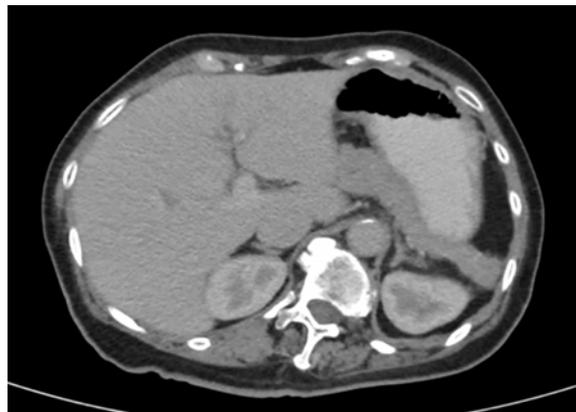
Horizontal view of abdominal CT scan at 6 months after operation.
